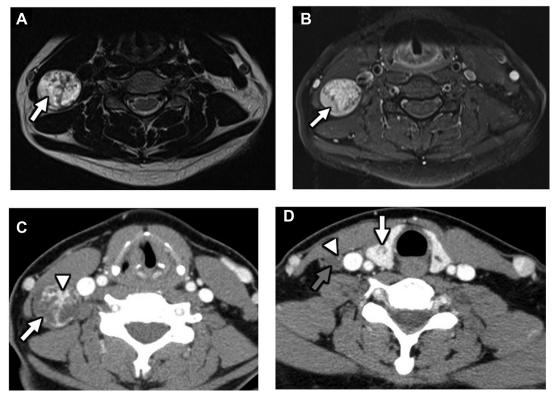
A 43-year-old woman with optic neuritis. (*A*) T2-weighted axial MR image of the cervical spine was performed to look for demyelination; however, a partially cystic/necrotic right level III lymph node was discovered (*white arrow*). (*B*) T1-weighted, contrast-enhanced axial fat-saturated MR image shows same node avidly enhancing (*white arrow*). Given the young age, thyroid cancer was suggested and CECT was obtained. (*C*) CECT axial image through the level of the thyroid cartilage demonstrates a partially cystic/necrotic right level III lymph node (*white arrow*) with areas of enhancement/calcification (*white arrowhead*). (*D*) CECT axial image at the level of the thyroid. There is a largely cystic/necrotic right level IV lymph node (*gray arrow*) with a punctate calcification (*white arrowhead*). Pathology showed papillary thyroid cancer with the primary cancer being located in the right thyroid lobe (*white arrow*).
